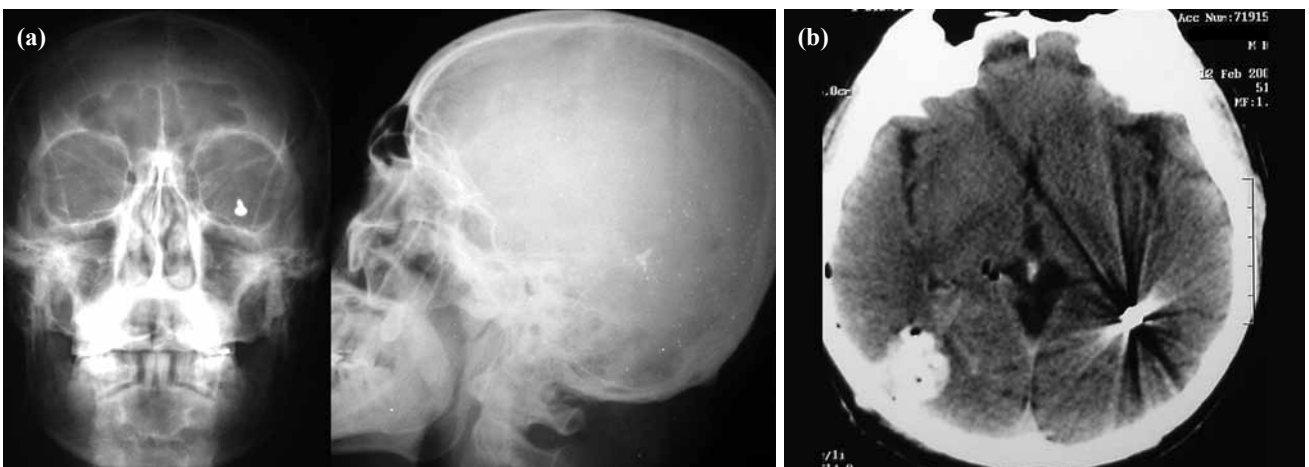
(a) X-ray shows metallic screw in the left deep parietal region. (b) CT scan shows metallic body and intracerebral hemorrhage along its trajectory.
